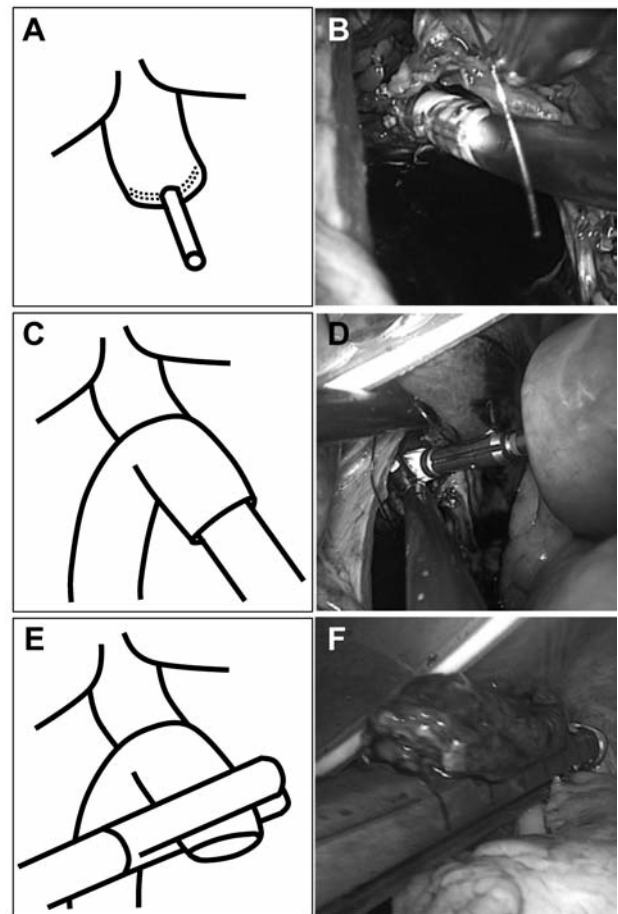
Esophagojejunostomy by the double stapling technique (DST) with a trans-orally inserted anvil (OrVil™). (A, B) After transection of the abdominal esophagus, the OrVil™ anvil was passed transorally through the larynx to the stapled esophageal stump. A small hole was created using an ultrasonic knife on the corresponding position of the stapled esophageal stump and the tube was pulled out into the abdominal cavity through the hole until the white plastic rubber ring was fully revealed. The connecting thread was cut and the tube was disconnected from the anvil. (C, D) A 25-mm circular stapler was inserted into the distal limb of the jejunum and introduced into the abdominal cavity from the extended left upper incision. The anvil and circular stapler were connected and an end-to-side esophagojejunostomy anastomosis was made. (E, F) The entry hole of the circular stapler was closed with a 60-mm linear stapler.
